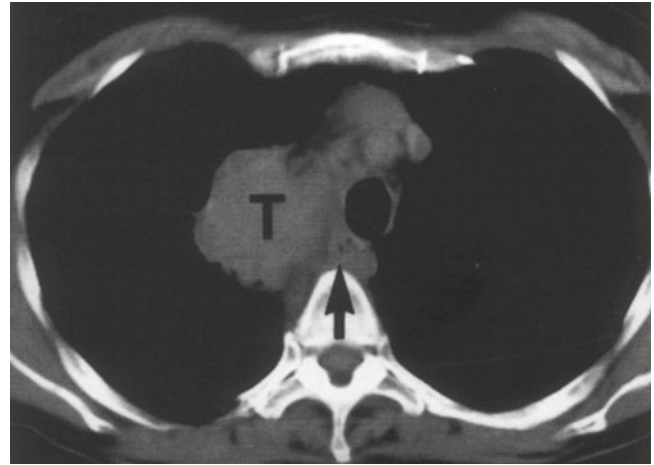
Axial CT image of a patient with NSCLC. The tumor is located adjacent to the mediastinum. Although there is an indication that the more ventral part of the tumor (T) is probably growing into the mediastinum, the more dorsal part might be separate. The arrow indicates the location of the esophagus. This tumor is graded as minimally a T3 based on the CT image alone. Additional EUS and EBUS examination can be used to better visualize the local situation
